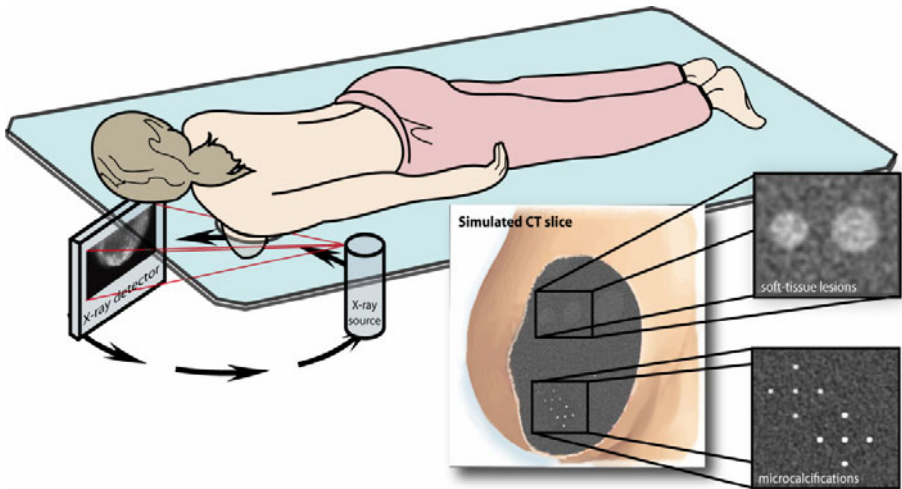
In dedicated breast CT, the patient will be scanned with low X-ray dose in prone position with only one breast exposed at a time. Calculations and preliminary measurements indicate that we will be able to display microcalcifications as well as or even better than in standard mammography. Soft-tissue lesions which are often obscured in mammography by overlying tissue will be displayed clearly without an increase in dose at decreased spatial resolution. Note: The two separate inserted displays of soft tissue lesions and of microcalcifications are derived from the same, single measurement by different processing.
